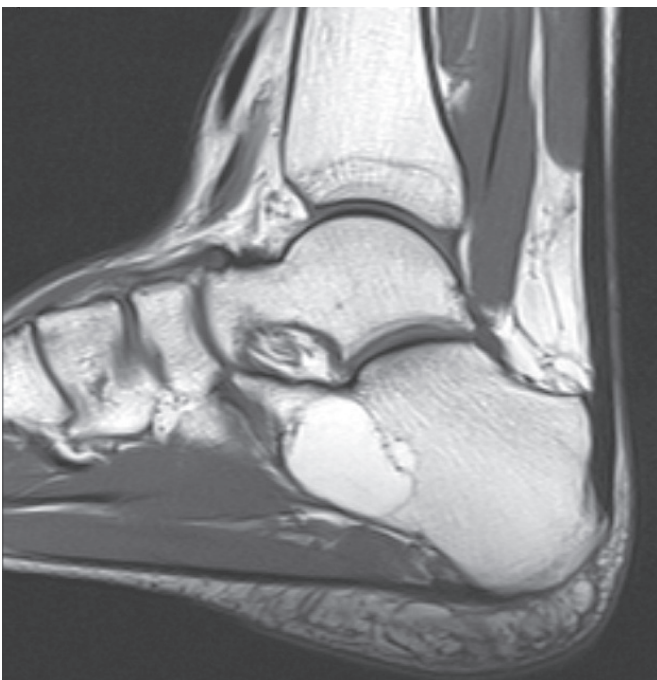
Sagittal T2 MRI image of a calcaneal lipoma
